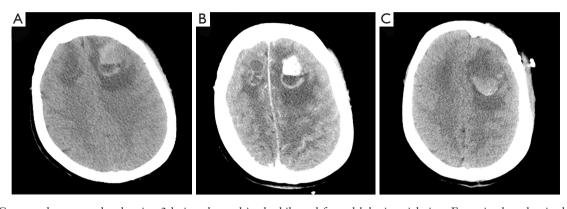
Computed tomography showing 2 lesions located in the bilateral frontal lobe in axial view. Extensive low-density lesions were located in the bilateral frontal lobe and the left irregular mass had high density (A). The masses were ring enhancement (B). Postoperative computed tomography showed total removal of the left mass after the first operation (C).
